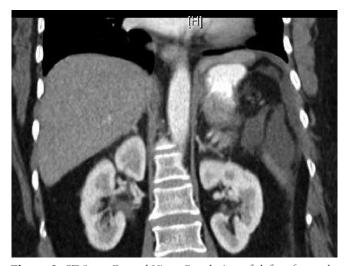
CT Scan, Frontal View. Resolution of defect 6 months status after repair.
